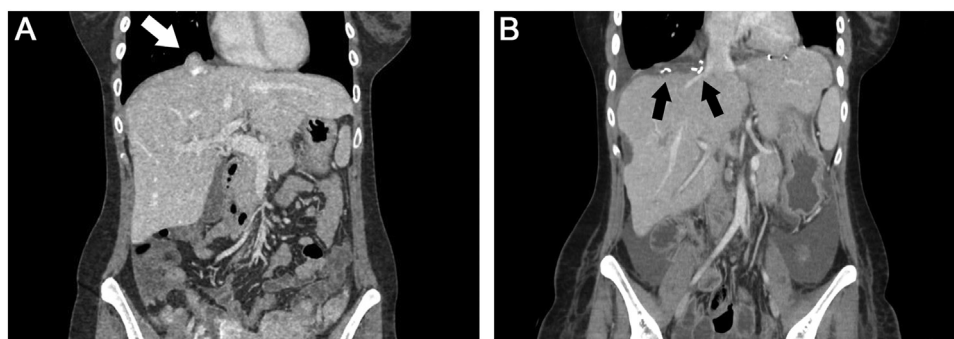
(A) Coronal reconstruction of a thoracoabdominal computed tomography scan performed before the intervention, showing a nodule of peritoneal carcinomatosis infiltrating the right diaphragm (white arrow). (B) A postoperative thoracoabdominal computed tomography scan was performed seven days after surgery. This coronal reconstruction shows the operated area of the right diaphragm with the absence of the previously observed metastatic lesion and the presence of staples (black arrows).
